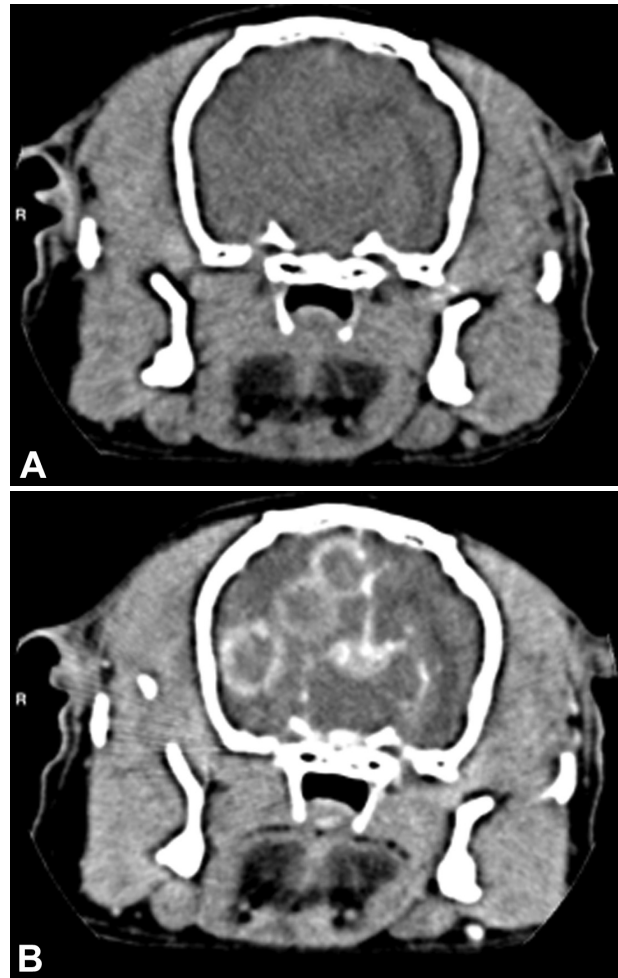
Transverse CT images of the head of a 10-year-old Pekingese that had progressive clinical signs including dull mentation, circling to the right, a right-sided head turn, head pressing, and, more recently, coughing, vomiting, anorexia, and melena. The images were obtained at a level just rostral to the tympanic bullae before (A) and after (B) IV administration of contrast agent. There are 3 strongly rim contrast-enhancing circular lesions in the right cerebral hemisphere with a leftward shift of the falx cerebri.
